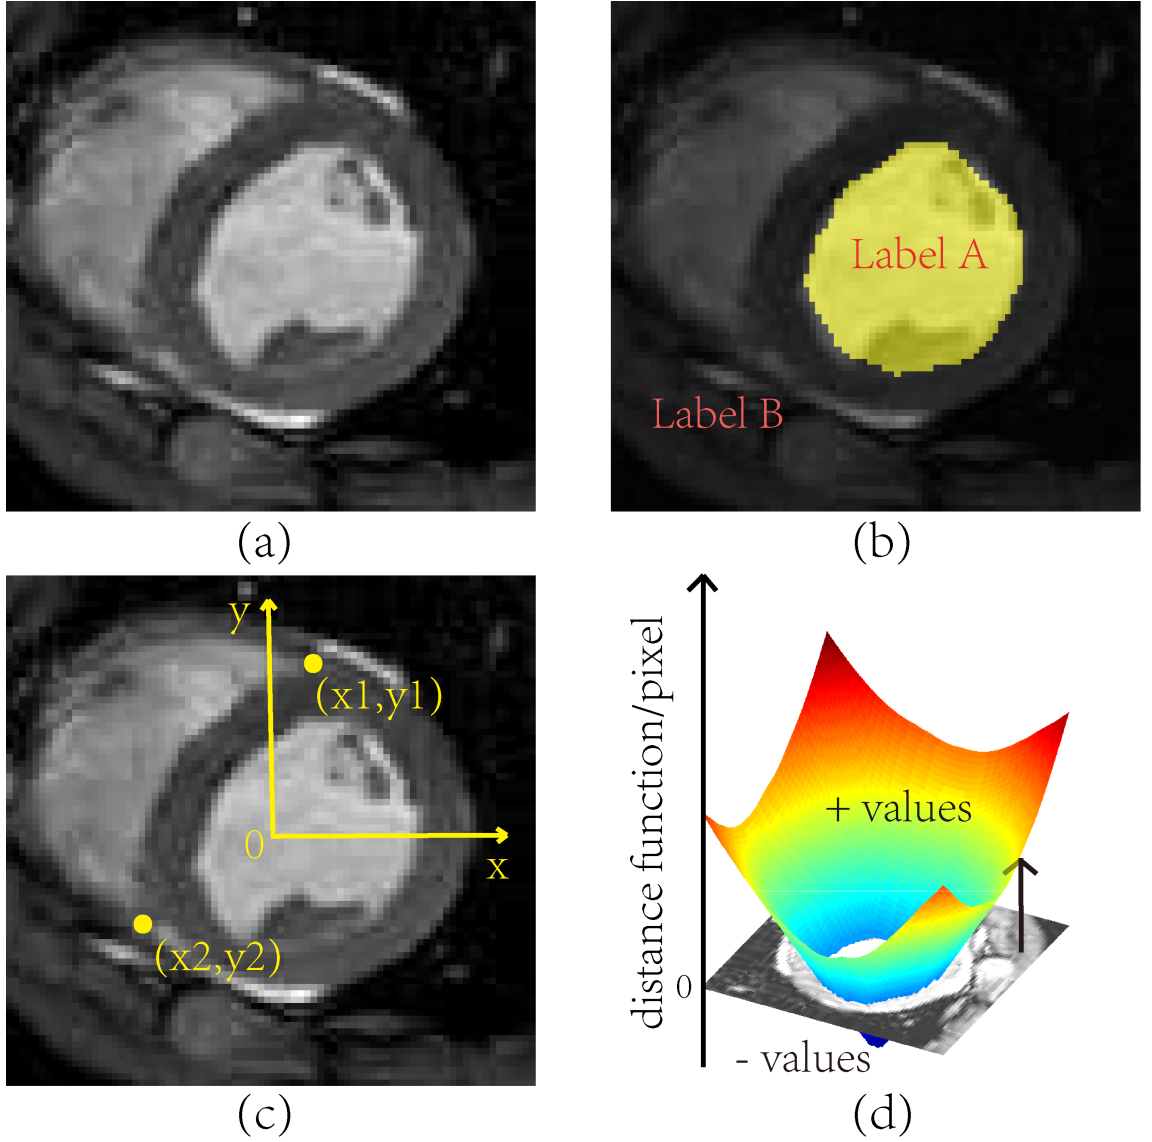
Cardiac MR image labeling for endocardium and RV insertion points. (a) Short-axis MR image of the heart. (b) Pixel labeling of the left ventricle chamber. (c) Labeling of right ventricle insertion points. (d) Level set representation of the left ventricle chamber contour (endocardium).
